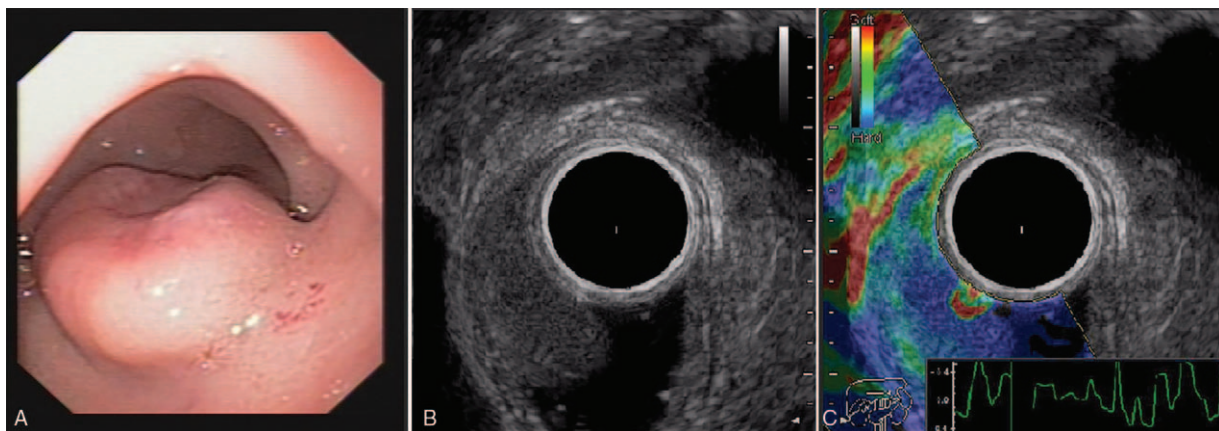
(A) Esophagogastroduodenoscopy showed a 20-mm polypoid lesion with a central ulcer in the posterior wall of the duodenal bulb. (B) Endoscopic ultrasound (EUS) showed a hypoechoic, hypervascular lesion with regular margins involving the mucosal, submucosal, and muscular layers. (C). EUS showed a blue predominant pattern at elastography.
